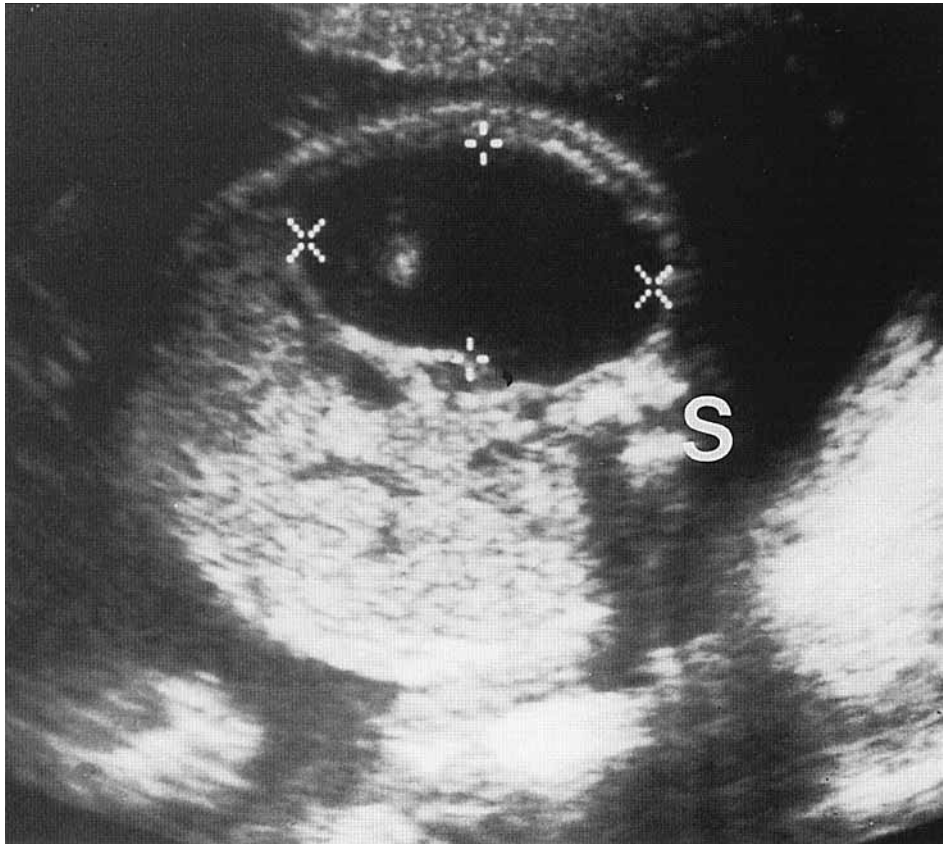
Transverse sonogram of the fetal abdomen at 28 weeks, MA. A cystic lesion is present within the left upper quadrant (calipers) (S: spine). (Images courtesy of Atis K. Freimanis, MD, and Teresa Kelley, MD, Department of Radiology, Michigan State University, East Lansing, Michigan.)
